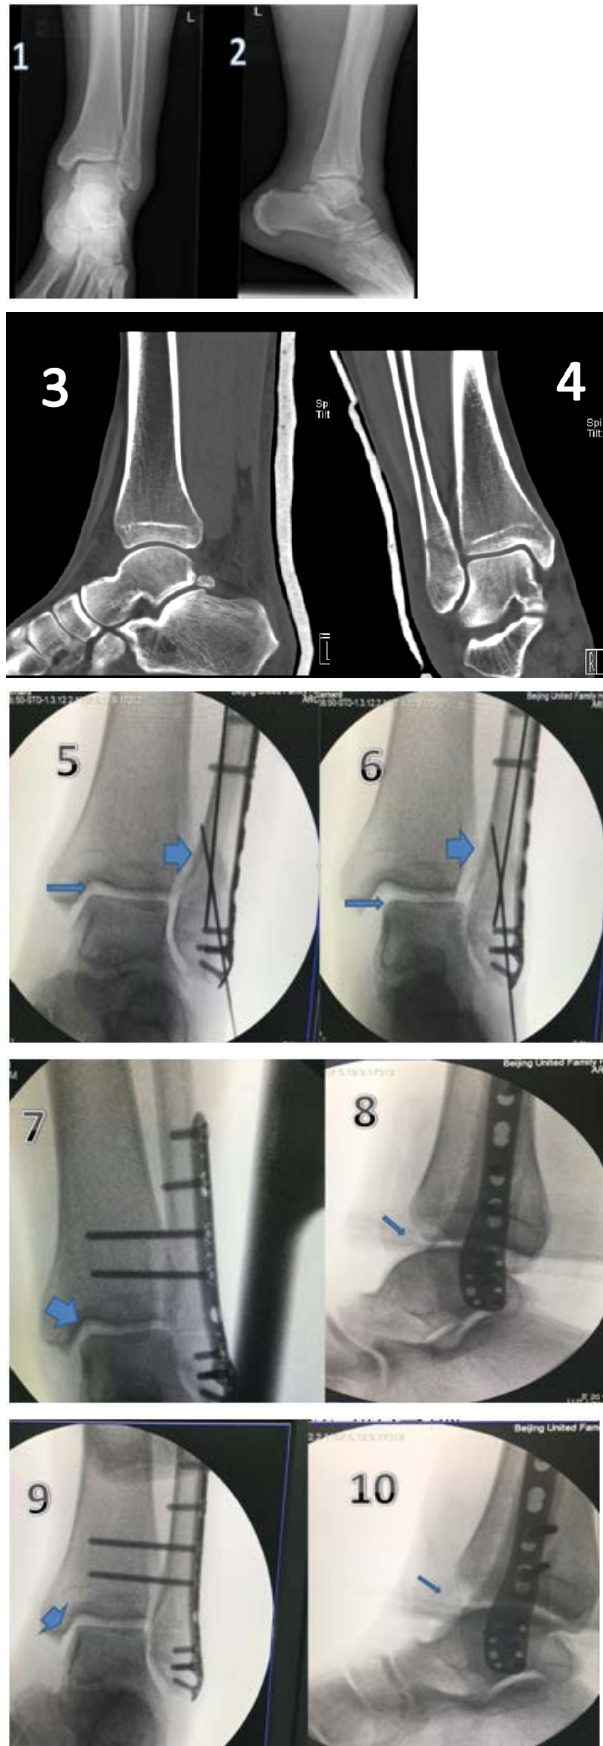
The radiographs show a Weber B lateral malleolar fracture without a medial malleolar fracture (1,2). CT shows no obvious anterior or lateral dislocation (3,4). Intraoperative radiographies show the medial joint space was clearly widened under the external rotation stress test (5,6). Intraoperative radiographs show, even after trans-syndesmosis screws were inserted, that medial joint space was slightly widened with varus external-rotation stress (7) and that the talus was obviously shifted in an anterior direction with anterior-posterior stress (8). Finally, after the repair of the deltoid ligament and the anteromedial ankle joint capsule, intraoperative radiographs, with another sets of stress tests, showed medial joint space was not widened and there was no talar anterior translation (9,10).
